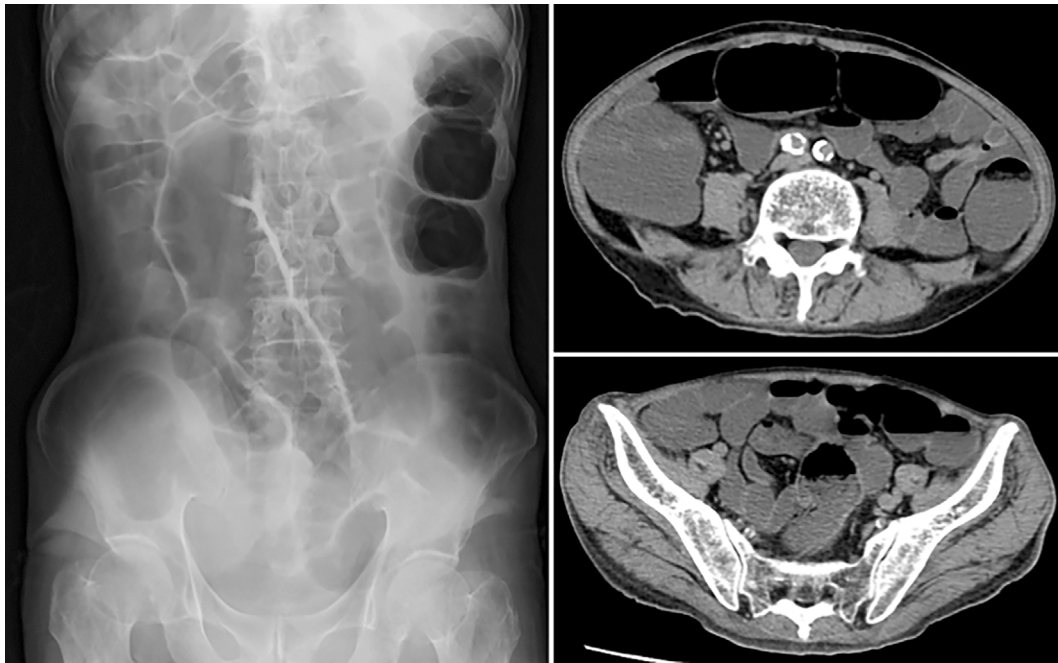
Plain abdominal radiography and abdominal computed tomography show continuous dilation of the entire intestinal tract.
